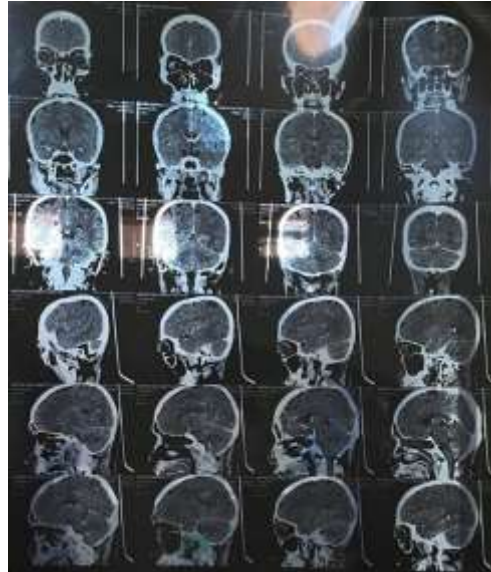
Head CT Scan Without Contrast
